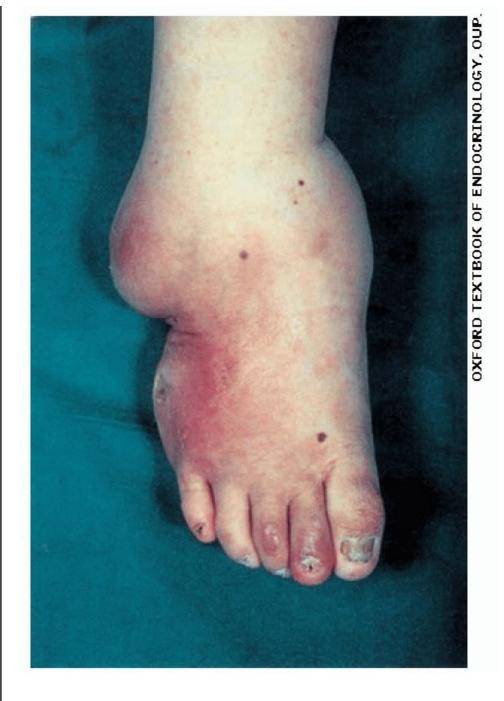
Charcot (neuropathic) joint, caused by loss of pain sensation, leading to ↑mechanical stress (unimpeded by pain) and repeated joint injury. Swelling, instability and, eventually, deformity, may develop, as seen here. ►Early recognition is essential. Treatment: rest (bed rest or non-weight bearing crutches) and immobilisation by a total contact cast until oedema and local warmth reduce and bony repair is complete (~2-3 months). The role of bisphosphonates is under investigation. Charcot joints are also seen in tabes dorsalis, syringomyelia, and leprosy. For an X-ray, see p526.
